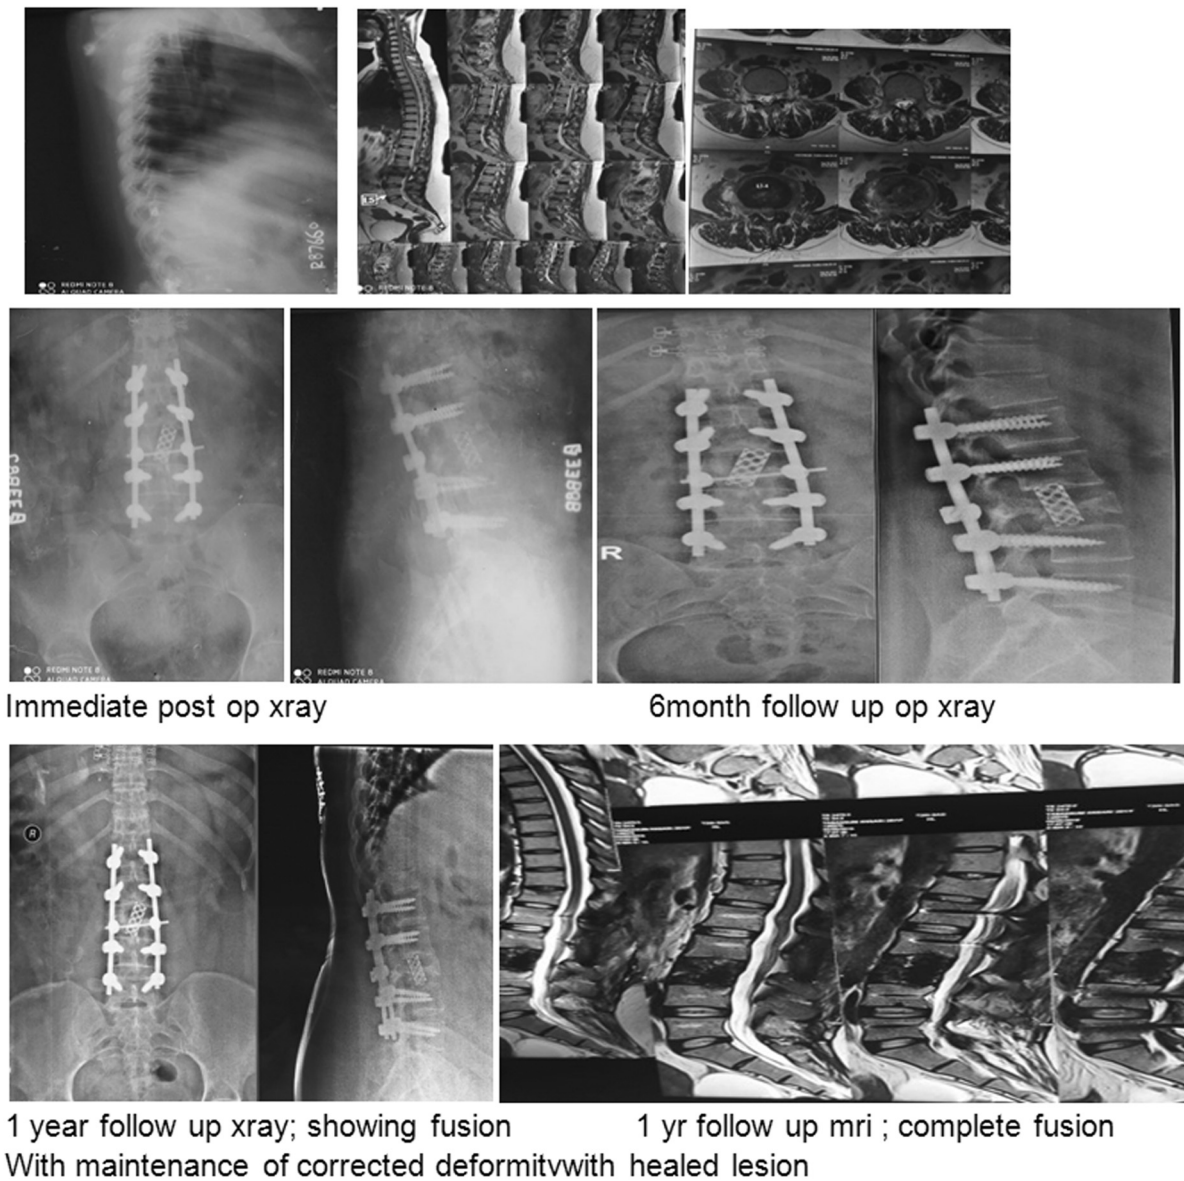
Case: 28 year female with L2-L3 spondylodiscitis, MRI showing pre- and paravertebral abscess.
